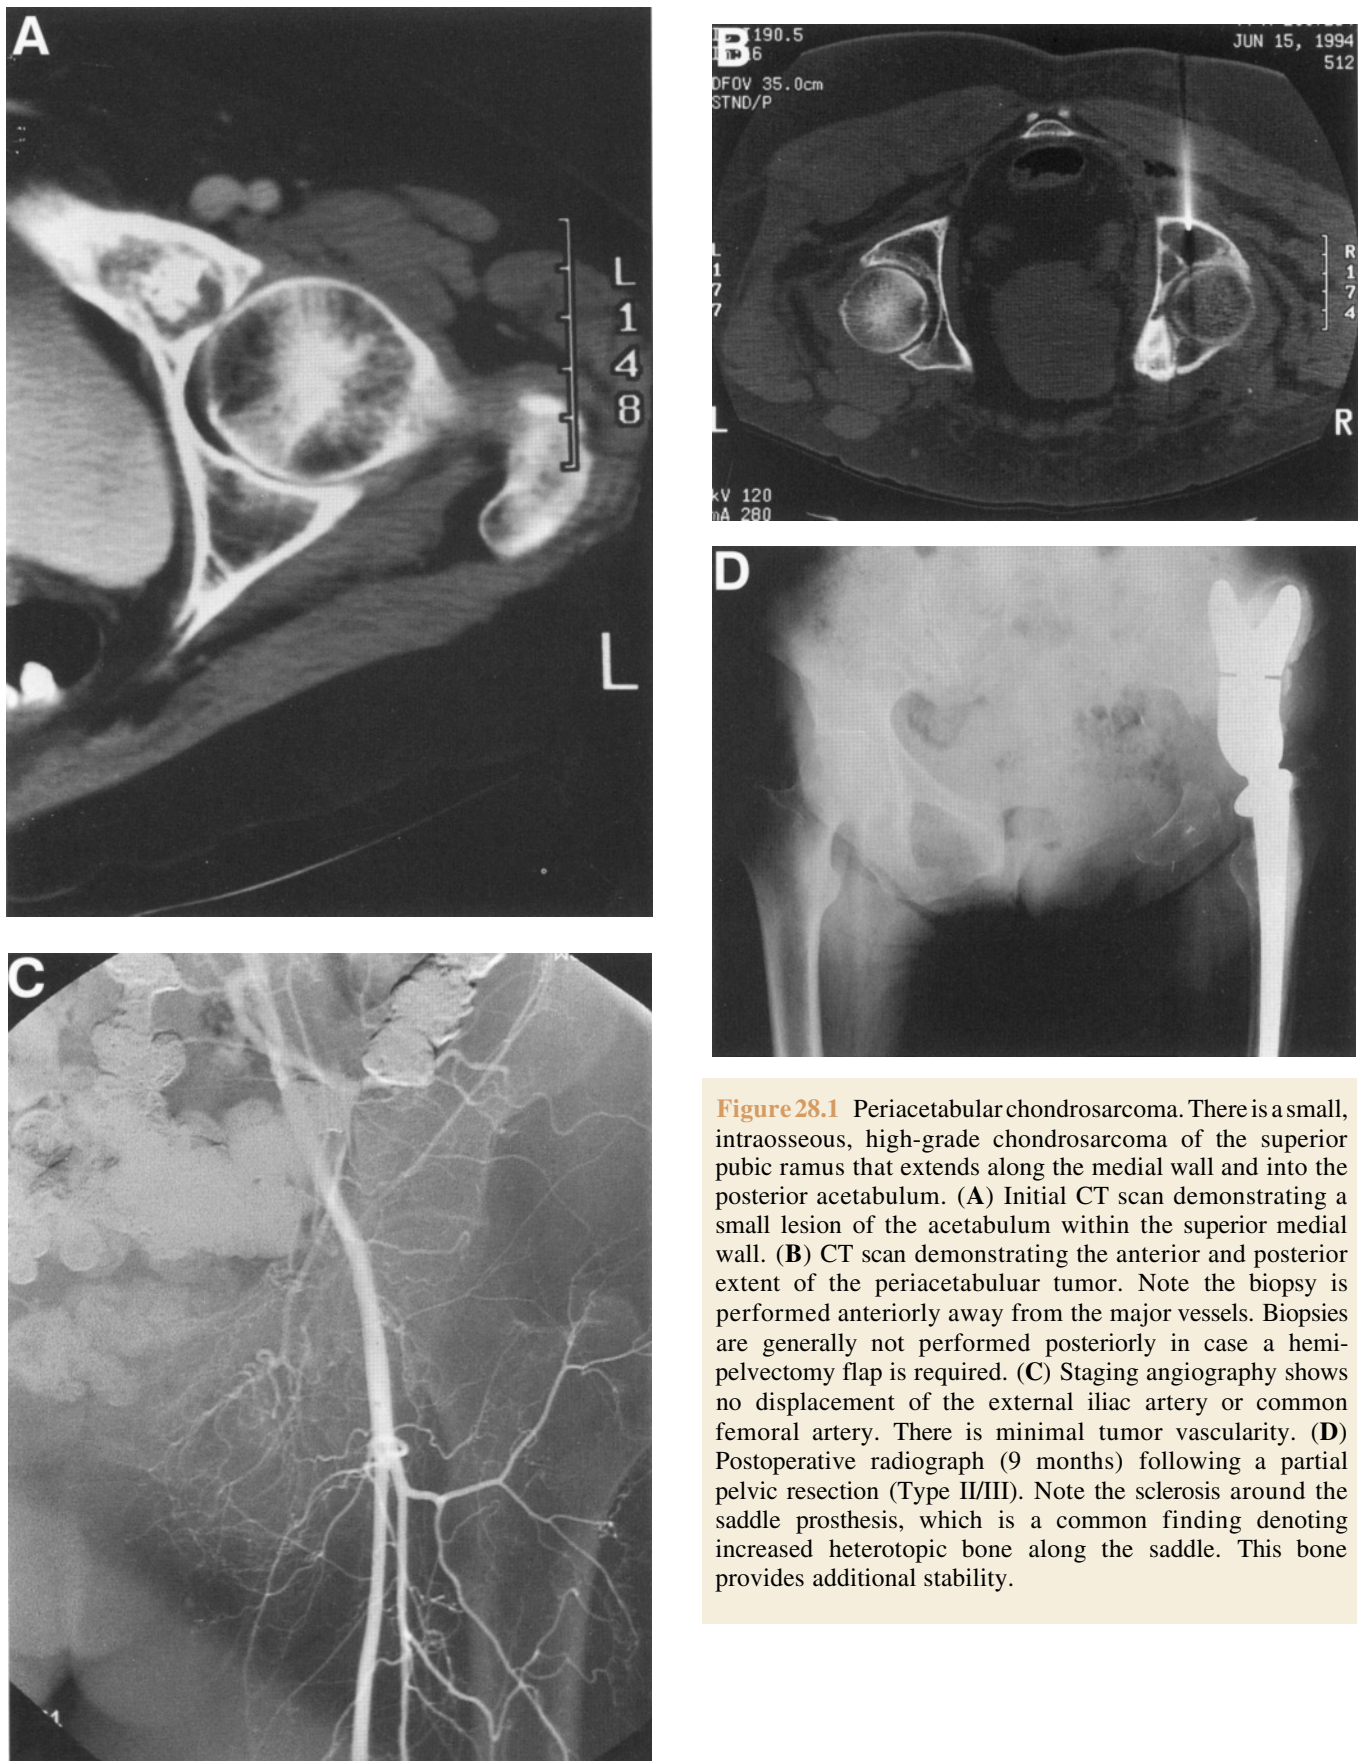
Periacetabular chondrosarcoma. There is a small, intraosseous, high-grade chondrosarcoma of the superior pubic ramus that extends along the medial wall and into the posterior acetabulum. (A) Initial CT scan demonstrating a small lesion of the acetabulum within the superior medial wall. (B) CT scan demonstrating the anterior and posterior extent of the periacetabular tumor. Note the biopsy is performed anteriorly away from the major vessels. Biopsies are generally not performed posteriorly in case a hemipelvectomy flap is required. (C) Staging angiography shows no displacement of the external iliac artery or common femoral artery. There is minimal tumor vascularity. (D) Postoperative radiograph (9 months) following a partial pelvic resection (Type II/III). Note the sclerosis around the saddle prosthesis, which is a common finding denoting increased heterotopic bone along the saddle. This bone provides additional stability.
